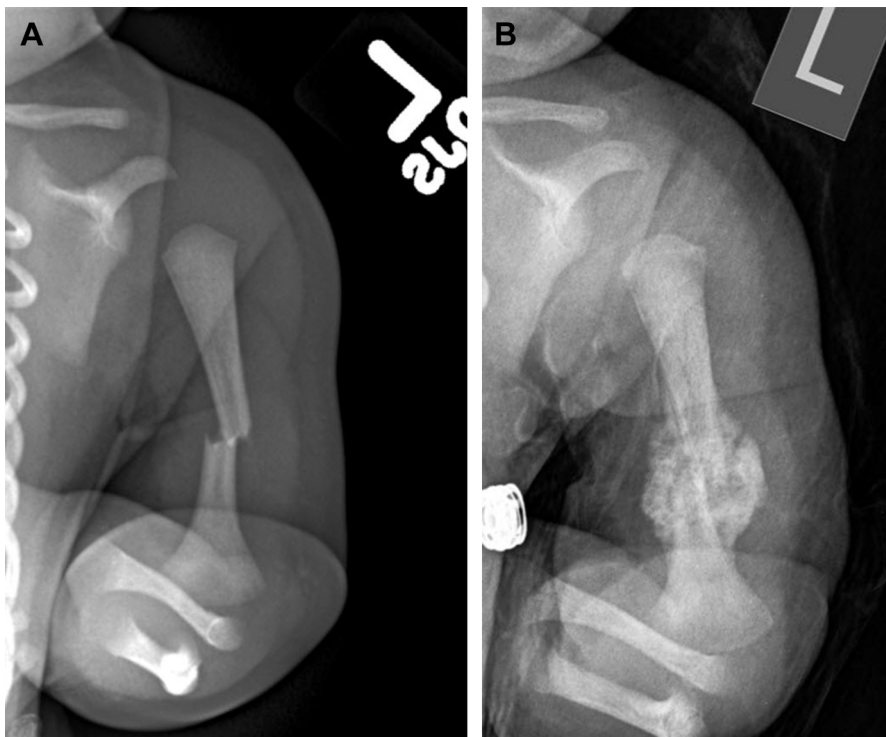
Newborn infant boy with left arm swelling after difficult breech delivery. (A) Initial frontal radiograph of the left humerus demonstrates transverse acute midshaft fracture. (B) Follow-up radiograph obtained at 21 days of age demonstrates extensive callous formation and periosteal reaction consistent with interval healing.
